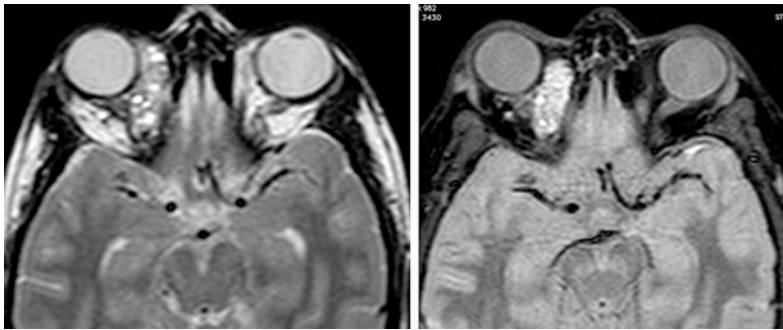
A 16 years old girl with microcystic lymphatic malformation. Axial T2WI and FLAIR WI with fat suppression images demonstrate right orbital microcystic lymphatic malformation showing multiple microcysts (less than 1 cm in size) of hyperintense T2 signal
